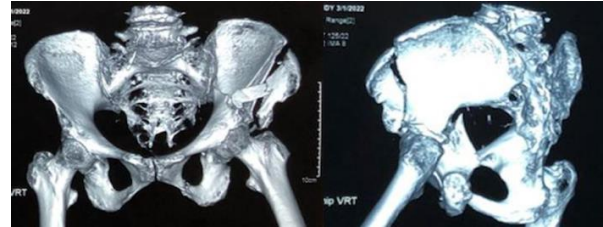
Show a 3D reconstruction of patient CT Pelvic
